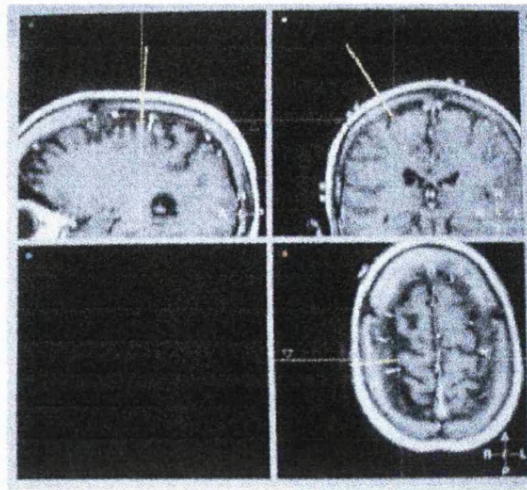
Example of a point on the surface of the brain identified on 3 orthogonal planes. The yellow line indicates the arm which the neurosurgeon holds and points to the brain, while simultaneously identifying the region on the MRI (such as a site inducing movement during cortical stimulation or an electrode position from a subdural grid). This point is relocated and visualised on the same MR image post-operatively and shown on the 3-D reconstruction.
